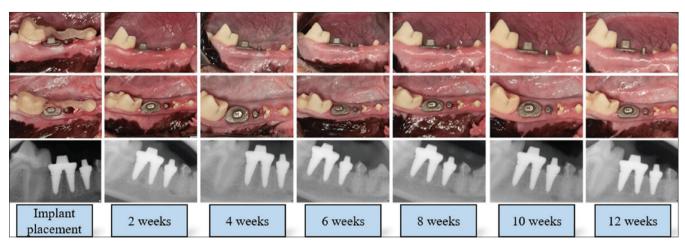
Clinical and radiographic photographs of single- and double-root 3D-printed dental implants, captured at the time of placement and at 2, 4, 6-, 8-, 10-, and 12-weeks post-implantation. Protective caps were removed two weeks after placement to assess plaque control and implant stability. The images show no signs of peri-implant inflammation, indicating successful integration and healing of the implants. Reprinted with permission from Springer Nature [20]
